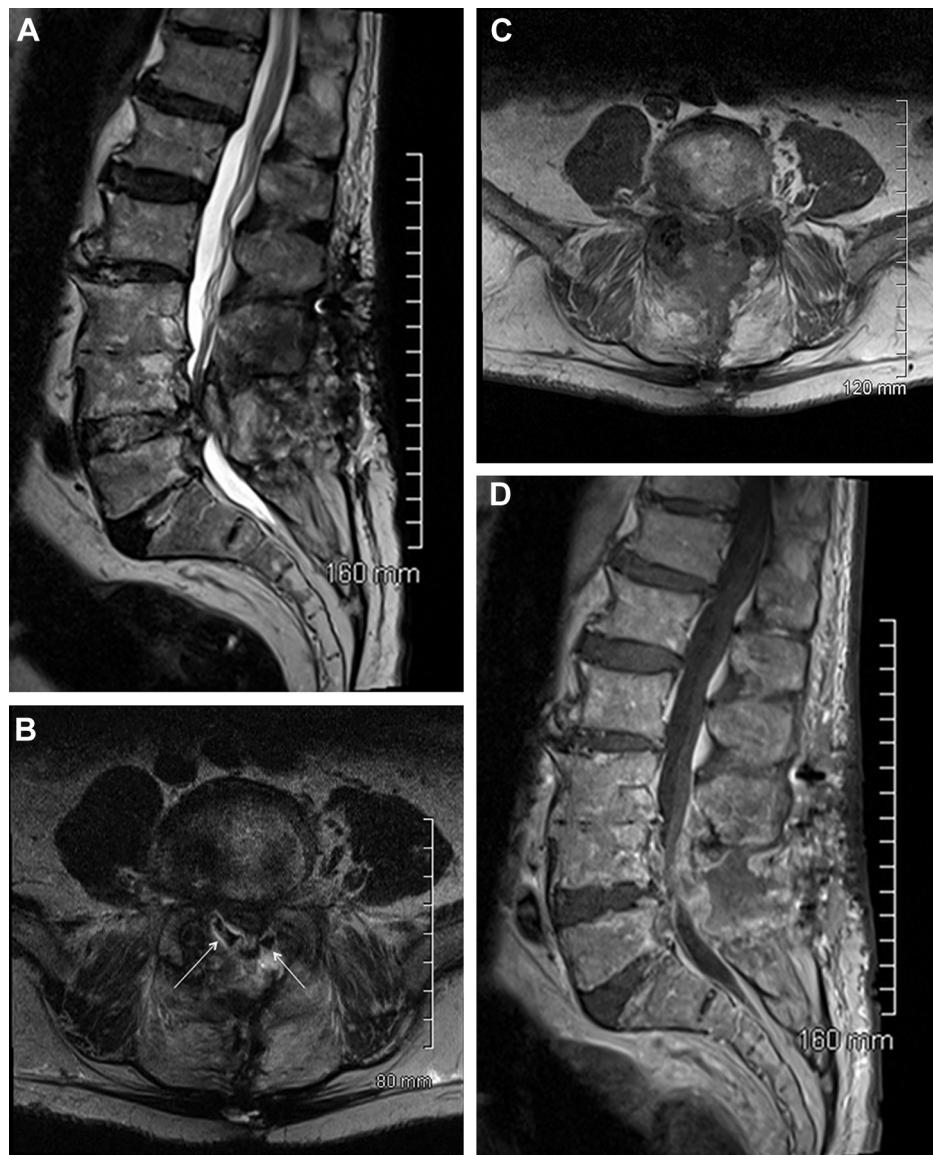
(A) T2-weighted sagittal and (B) axial images obtained on Day 17 demonstrating cauda equina compression at L4/L5 due to frank hypointense masses surrounded by areas of hyperintensity (B, arrows). These epidural masses were isointense on T1-weighted images relative to the intensity of the cerebrospinal fluid signal (axial image, C), with mild peripheral enhancement after gadolinium administration (sagittal image, D).
